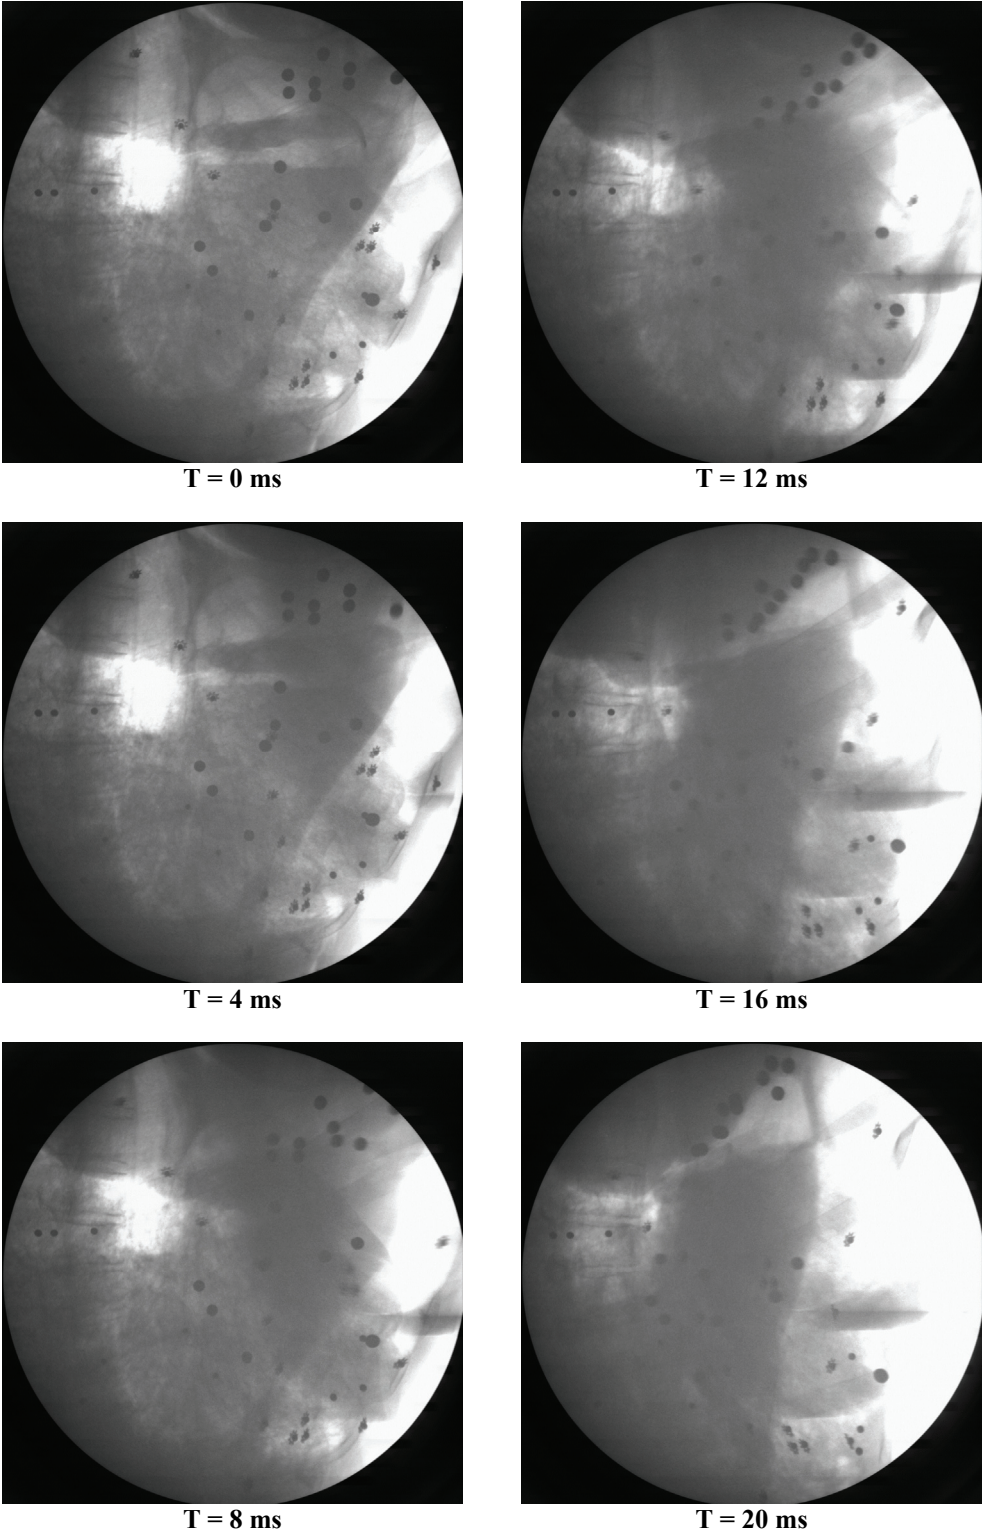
Thoracic rigid-disk impact x-ray image sequence. §
